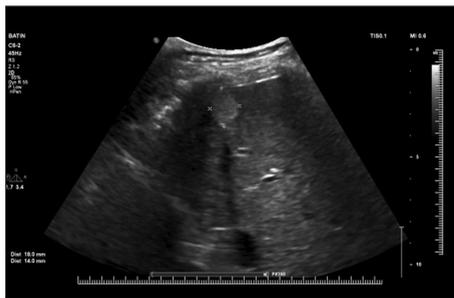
Hyperechoic liver lesion on sonographic examination.
